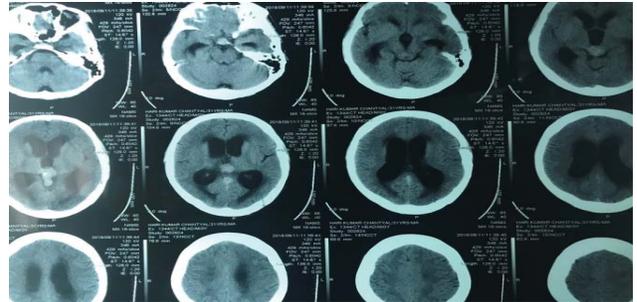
CT Scan shows hyperdense lesion in the posterior part of third ventricle associated with hydrocephalus.
